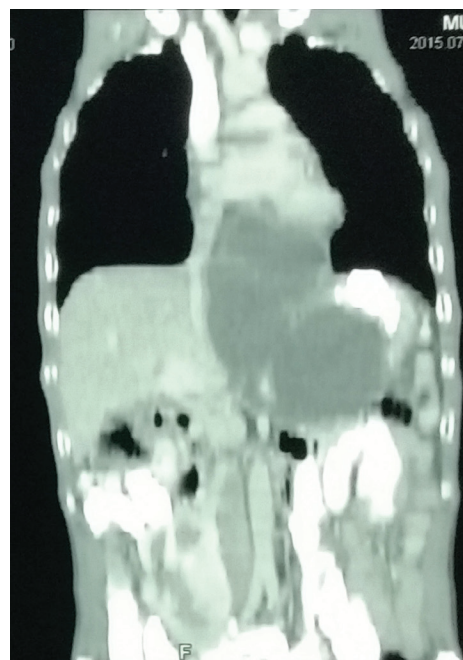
CT chest coronal view showing mediastinal pseudocyst.
